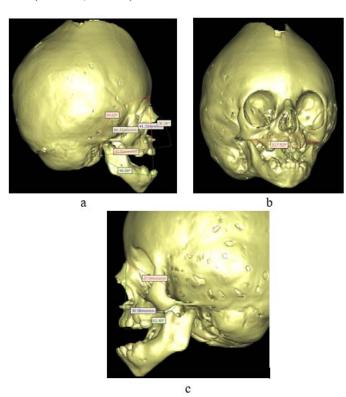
Roentgenographic data of the patient M. 3 years old. Oxycephaly, upper micrognathia. Indices of parameters of the facial triangle (a), zygomaxillary angle (b), alveolar process (c).
